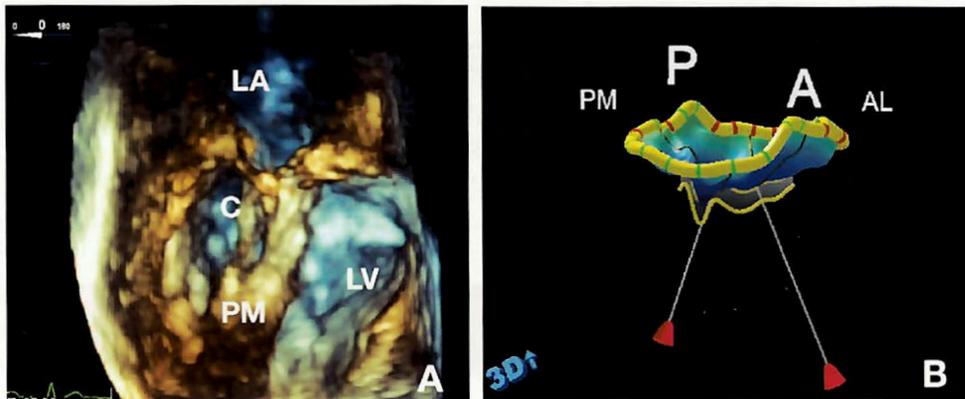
Live 3D transesophageal image of the mitral valve complex. Panel A shows the postero-medial papillary muscle (P), chordae tendinae (C), and mitral leaflets. Quantitative analysis (panel B) can be performed to assess a host of novel valve parameters including mitral annulus area and geometry, leaflet area and tenting volume, and tethering distance to papillary muscles. These parameters are becoming increasingly important for surgical valve repair procedures.
